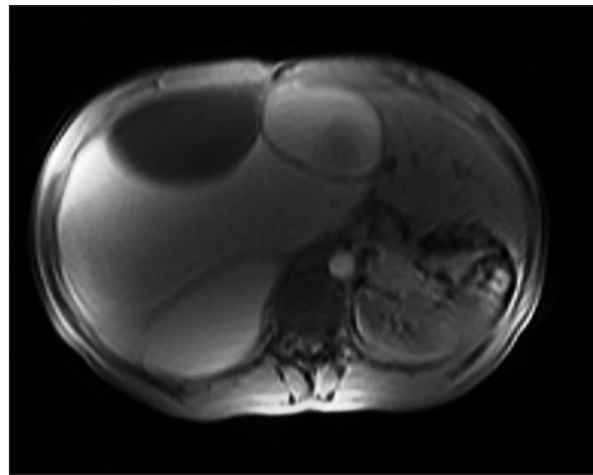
MRI scan, mass in the liver with hydatid cyst.
